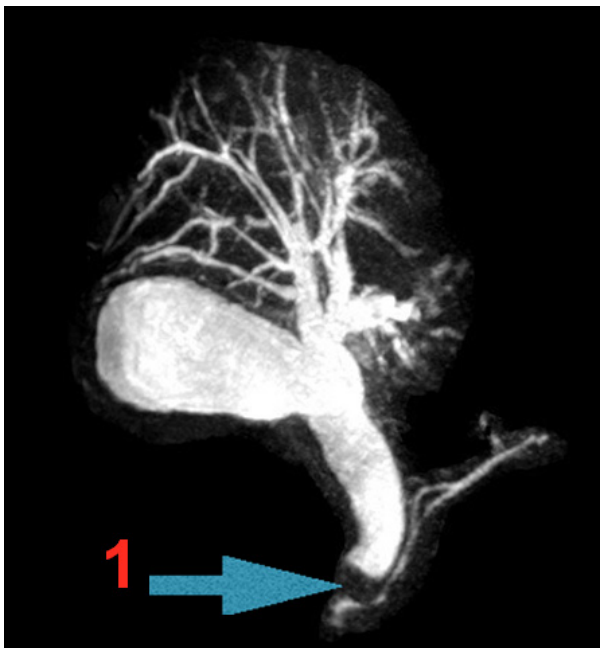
Magnetic resonance image. 1: stone.
